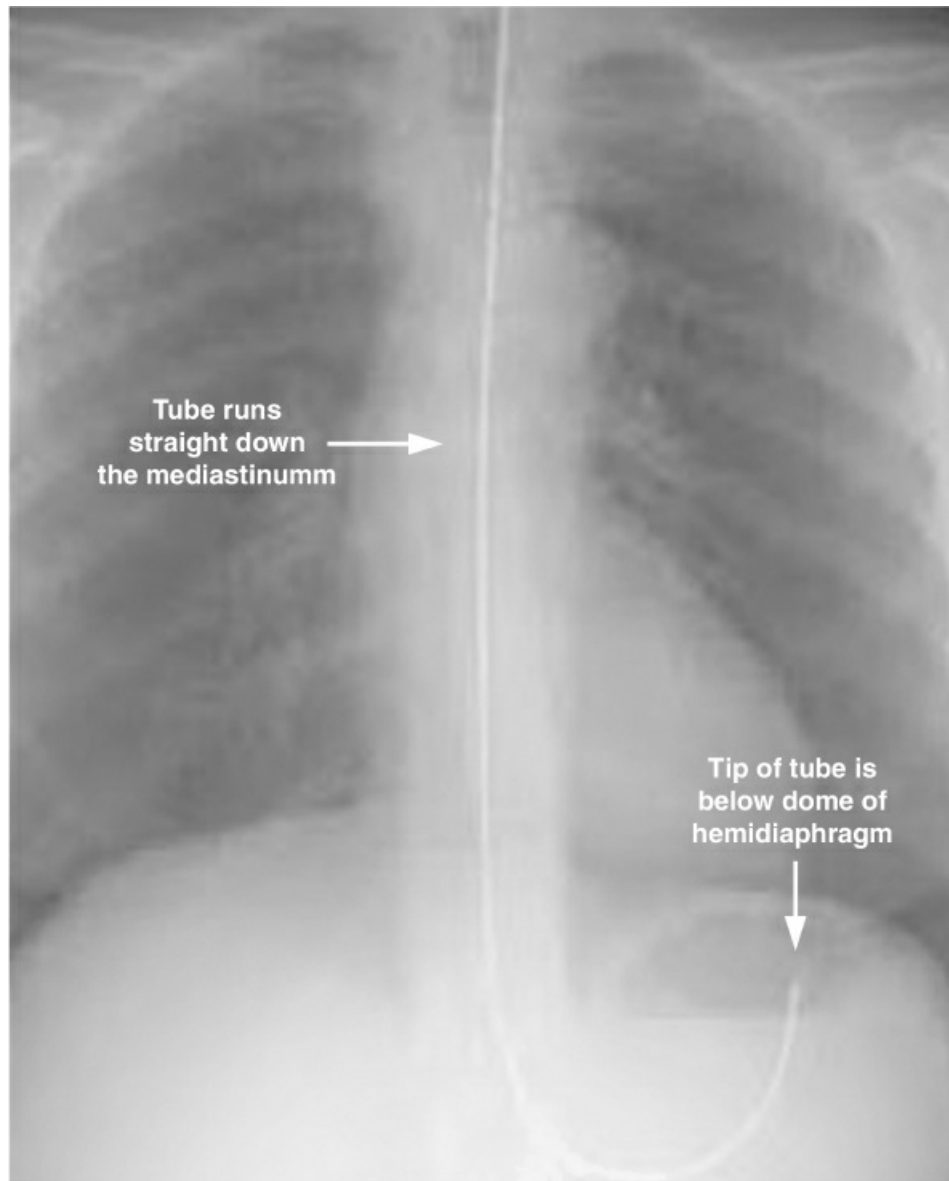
Portable chest x-ray showing the proper placement of a nasogastric feeding tube. Feedings should not commence until proper placement of the tube is verified radiographically. Image from Reference 31.
